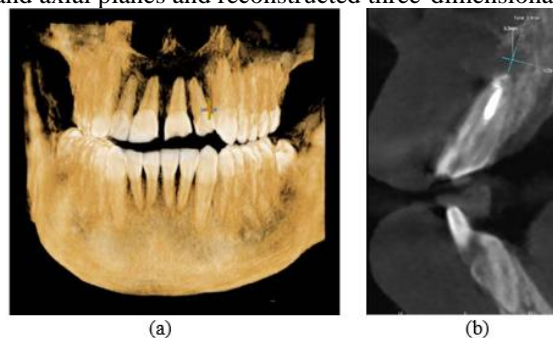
Preoperative CBCT showing the extent and size of periapical lesion
